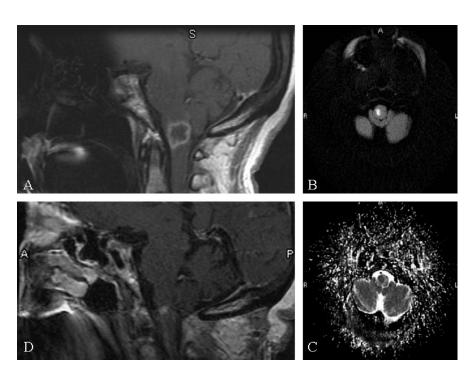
(A) A 1.8×1.4 cm peripherally enhancing mass expanding the cervicomedullary junction on MRI. (B) An area of restricted diffusion (C) with a corresponding low apparent diffusion coefficient is shown within the center of the lesion. (D) Five months after treatment, the lesion had improved significantly.
